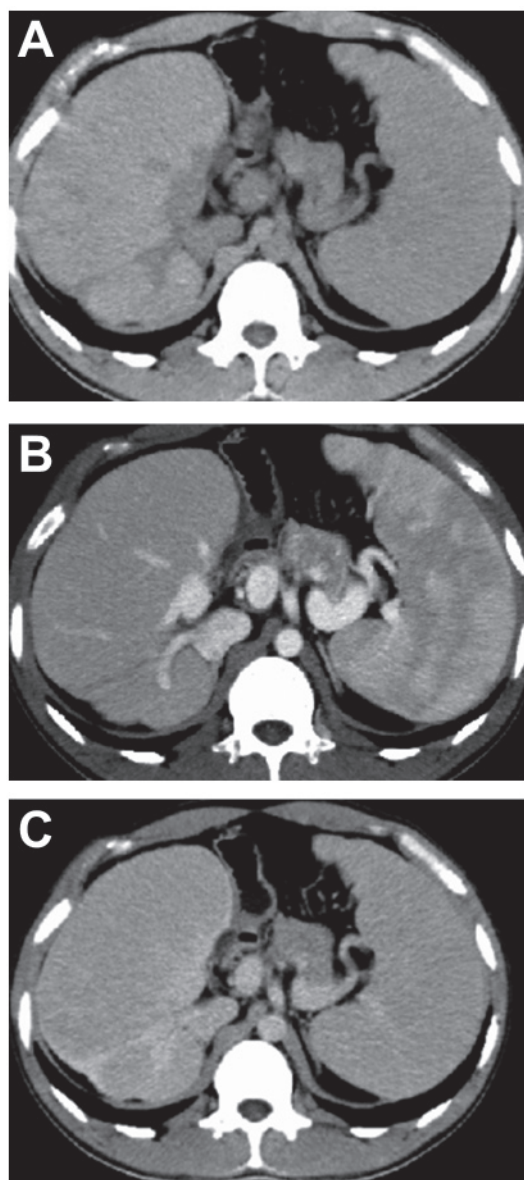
Case Two. (A) A CT scan showing an irregular mass at the back of the inferior vena cava and the liver; its density was uniform and the mass was clearly divided from normal liver tissue. (B) Enhanced scanning showed hepatic veins connected to the inferior vena cava. (C) Delayed phase: The mass had the same density as normal hepatic tissue and was demarcated from normal liver tissue by an enhanced line.
